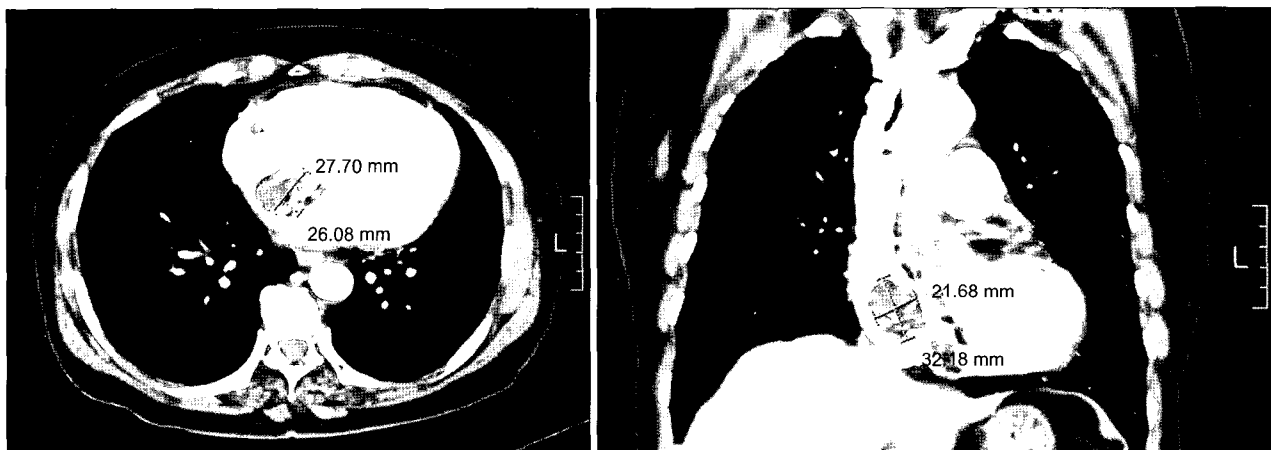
Transaxial (left) and coronal (right) images obtained by computed tomography show an lobular heterogeneous mass in right atrium.
